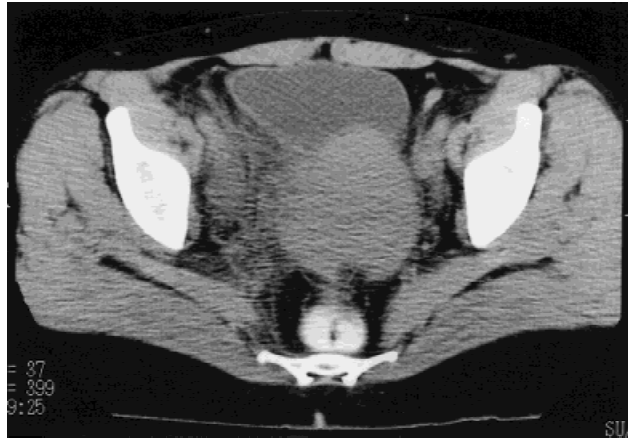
Abdominal CT scan showing infiltration of uterus and para-uterine tissues.
